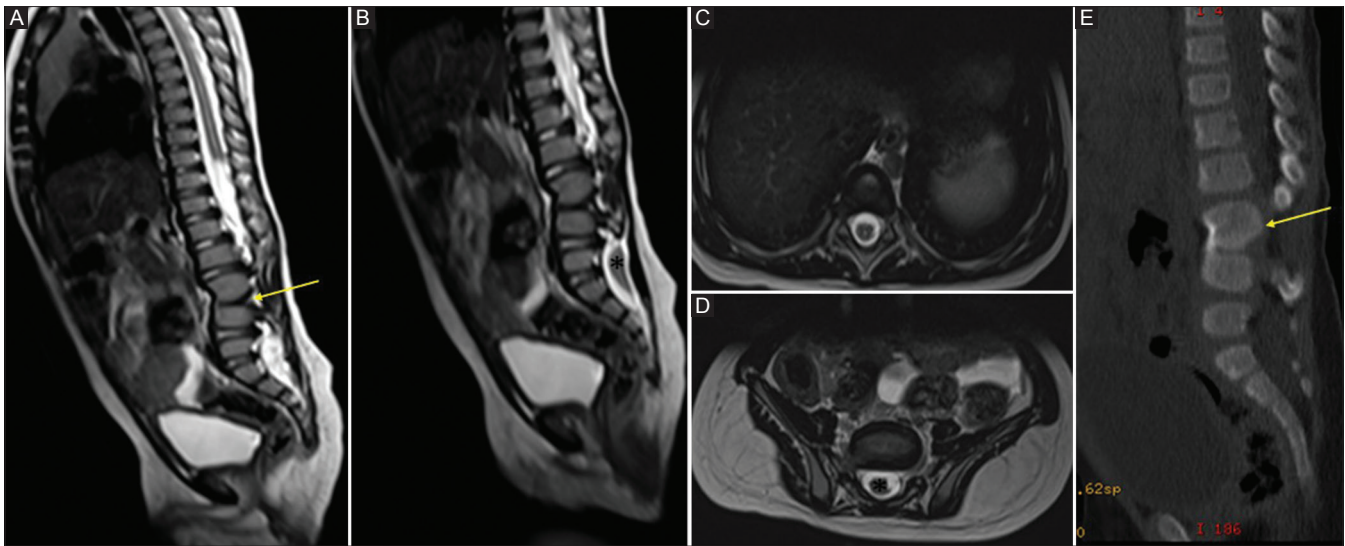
(A-E): Segmental spinal dysgenesis – Sagittal T2-weighted (A and B), axial T2-weighted (C and D), and sagittal CT reconstruction (E) of lumbosacral spine shows focal lumbar kyphotic deformity (arrow in A and E) with indiscernible spinal cord at the same level, normal spinal canal dimension of cranial segment (C) and bulky low lying caudal cord segment (*in B and D)
